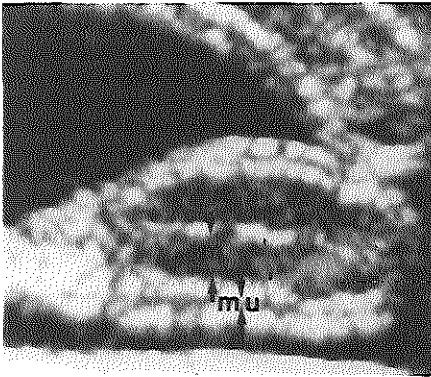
C. Transverse ultrasound scan of canine bowel *in vitro* surrounded by saline; hypoechoic bands represent mucosa (m) and muscularis (mu).
